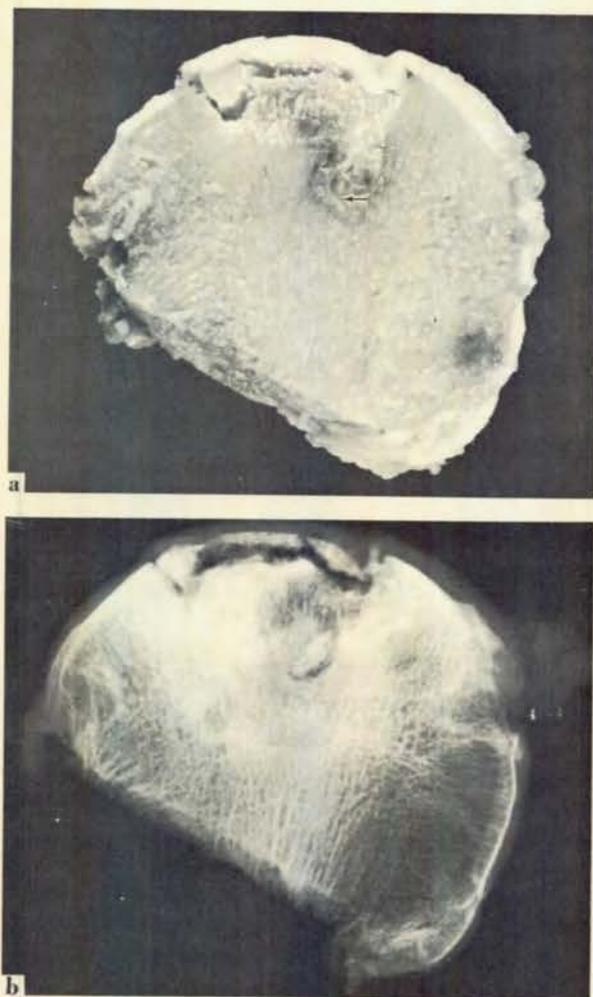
(a) Gross sagittal section of R femoral head, revealing Stage III lesion with subchondral fracture extending through necrotic bone with minimal thinning of cartilage. Small fracture cleft beginning at apex of necrotic lesion is marked with arrow. (b) Roentgenogram of same section showing early sequestrum formation with marked osteonecrosis.
